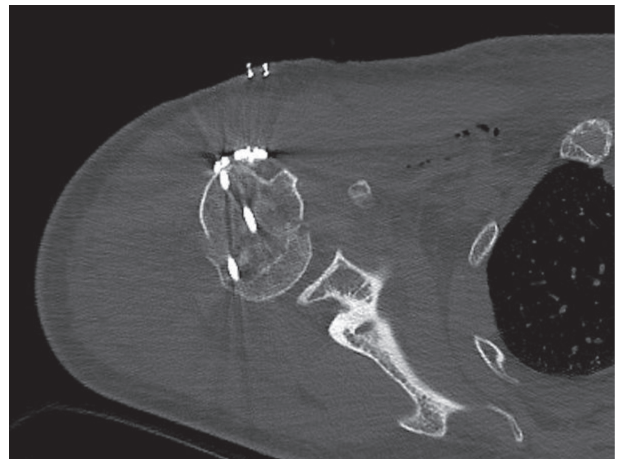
Preoperative CT scan (axial plane)
